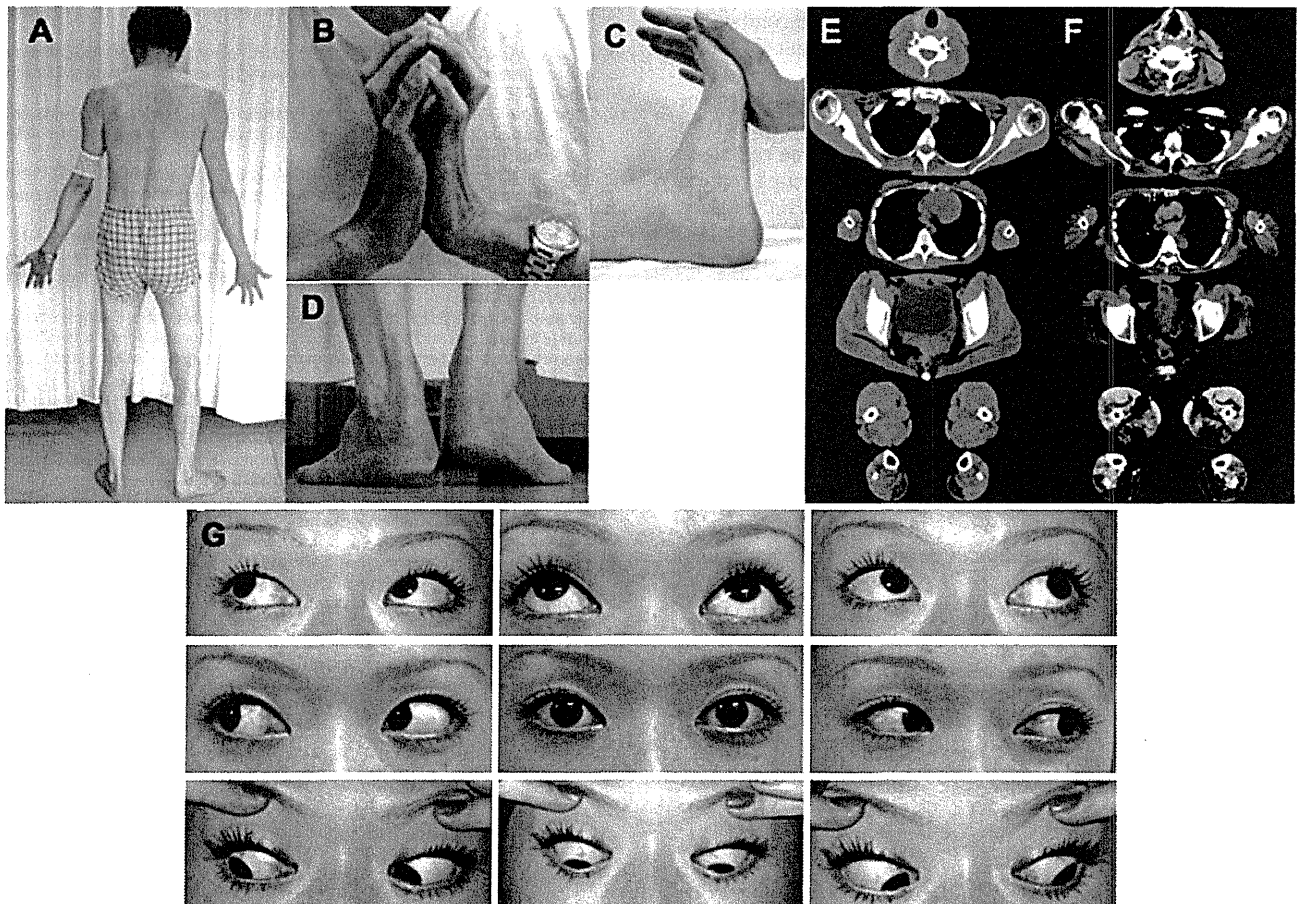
Photograph of Patient 3-6: distal muscular atrophy (A), joint contracture of fingers (B), and ankle contracture (C); patient could not put his heels on the floor because of the ankle contracture (D). Muscle CT of Patient 3-6 (F) and Patient 3-11 (E) depicting lower-leg muscle atrophy of the posterior compartment (gluteus maximus, hamstrings, gastrocnemius, and soleus), thigh abductor, and paraspinous muscles. Note the early involvement of the biceps femoris, gastrocnemius, and soleus in Patient 3-11 when she was 19 years old. Ophthalmoplegia and ptosis are not observed in most patients (G: Patient 3-11).
